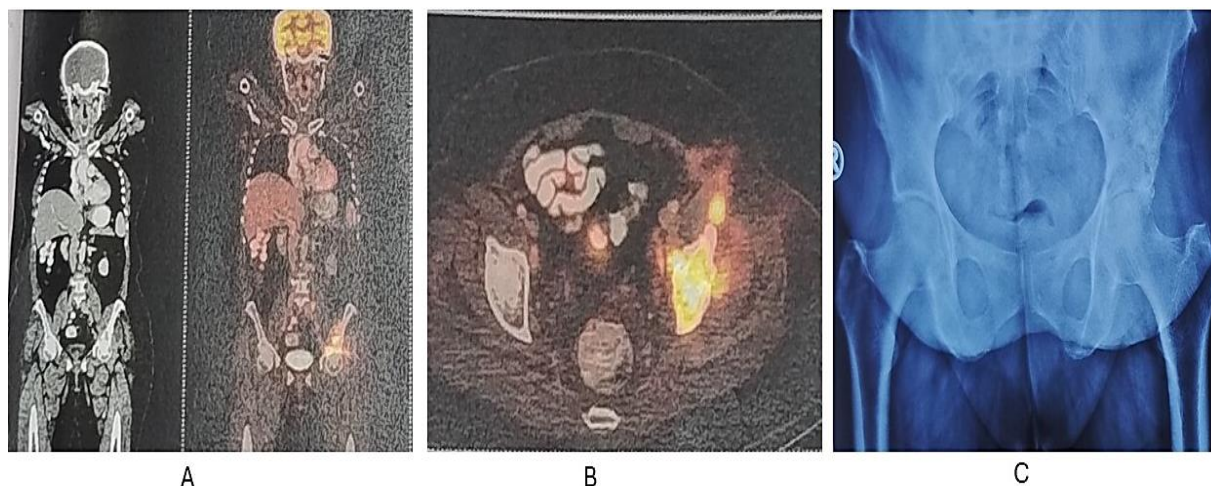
A and B) Positron emission tomography (PET) showing uptake around ilium and peri-acetabular region, with a maximum standardized uptake value (SUVmax) of 12; C) Anteroposterior (AP) view of pelvis with bilateral hip joint showing healed peri-acetabular lesion at last follow-up
